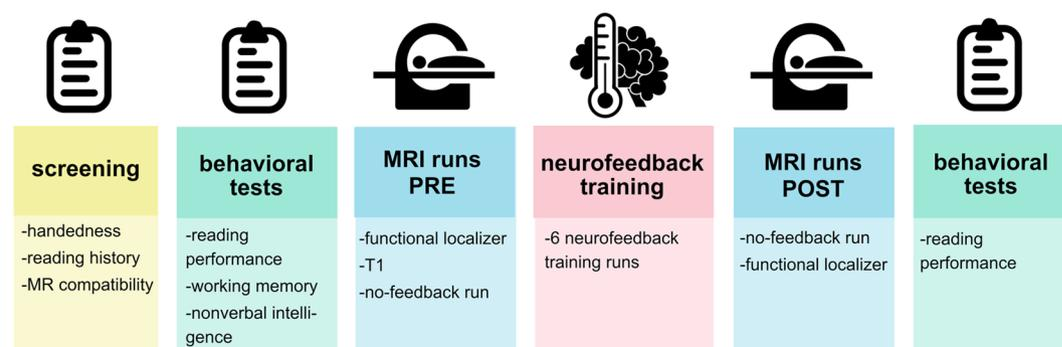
Experimental design. After an initial screening, participants underwent a set of behavioral tests on cognition and reading skills. During the MR session, participants first underwent a functional VWFA localizer, a T1-weighted anatomical scan, and a no-feedback run. Then, 6 runs of neurofeedback training were performed, followed by a break outside the scanner. After the break, participants repeated the no-feedback and functional localizer run in the MR scanner and the reading performance tests outside the scanner.
